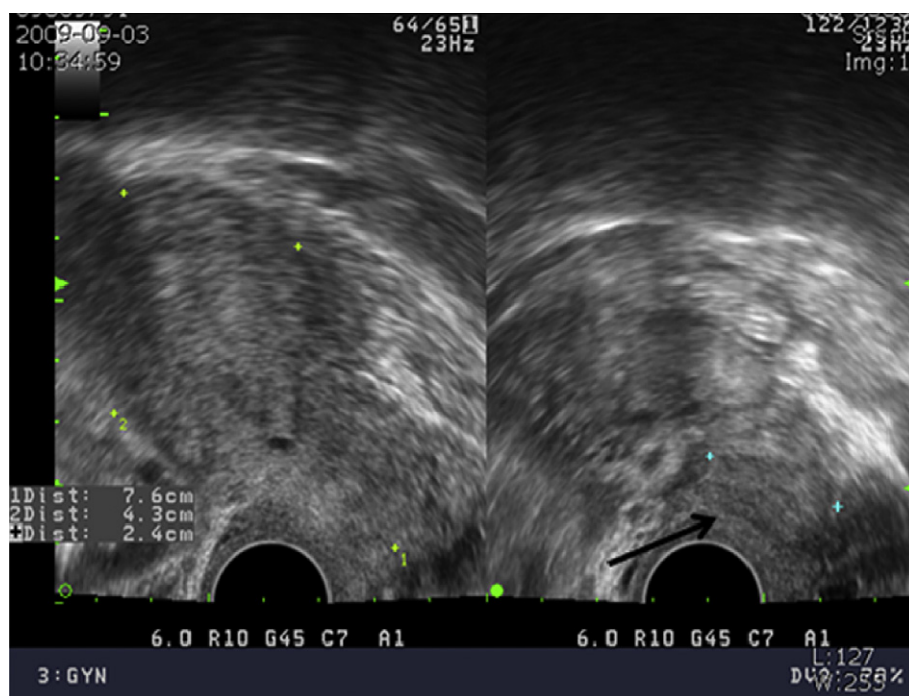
Transvaginal ultrasonography finding on the first visit. An approximate 2.4×2.0 cm mixed echogenic density observed in the left side of the posterior cervix of the uterus is suspicious of a cervical myoma (arrow).
